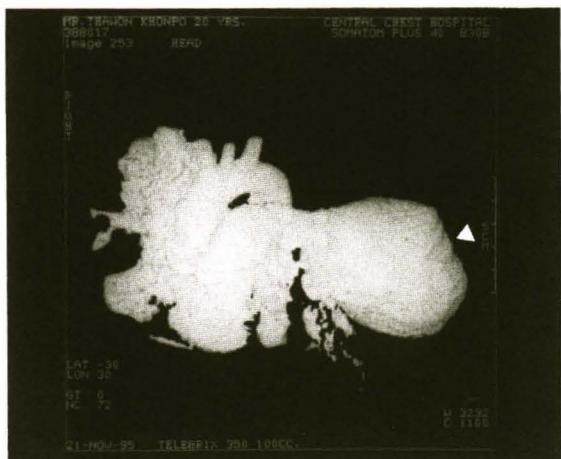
Spiral CT angiogram with 3D-reconstruction showing the left pulmonary artery aneurysm (arrowhead).
